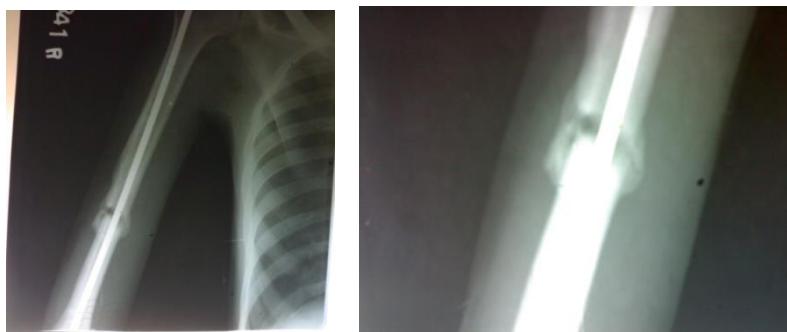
Radiographs at 3 ½ months showing more bridging callus on either side of the fracture both anteriorly and posteriorly
